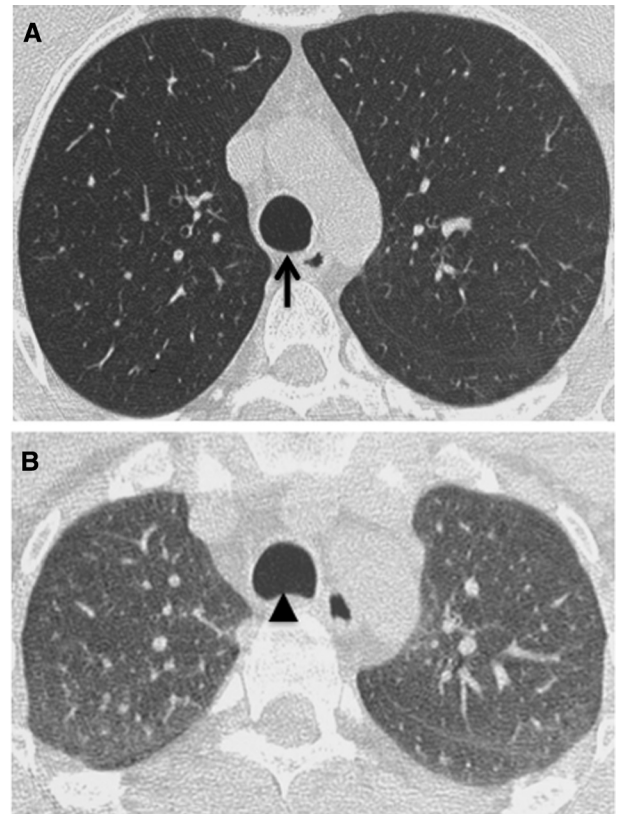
Normal inspiratory and expiratory computed tomography images. On inspiration (A), note that the membranous wall of the trachea bows posteriorly (arrow). On expiration (B), the membranous wall bows anteriorly (arrowhead). Note that the anterolateral walls change little in their morphologic appearance, due to the cartilaginous support.
